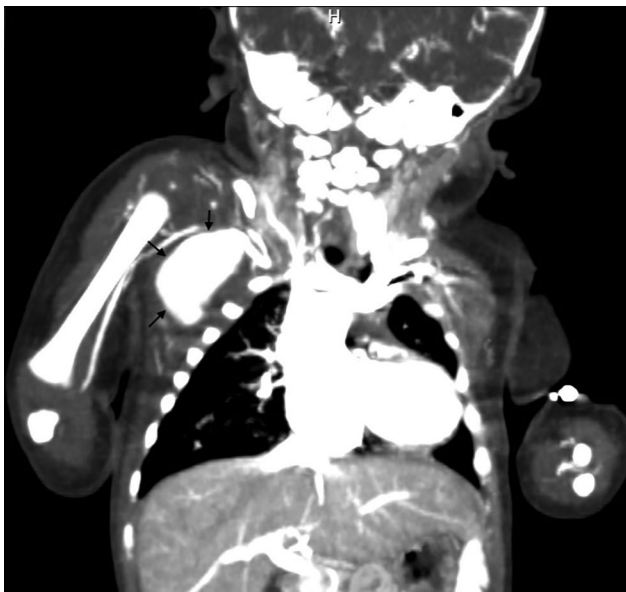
Contrast-filled pseudoaneurysm image in the right axillary region on computed tomography angiography.
